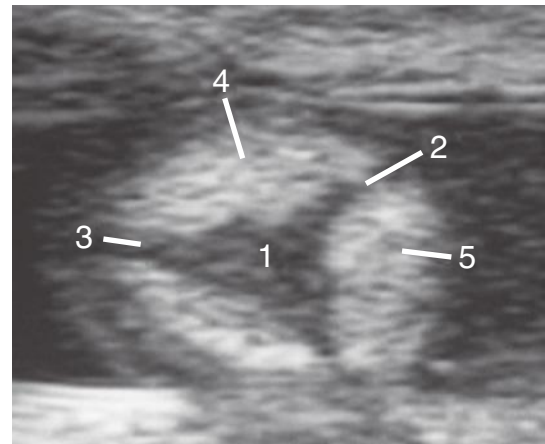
Transverse axial sonogram of the posterior fontanelle (1). 2, lambdoid suture; 3, sagittal suture; 4, parietal bone; 5, occipital bone.
